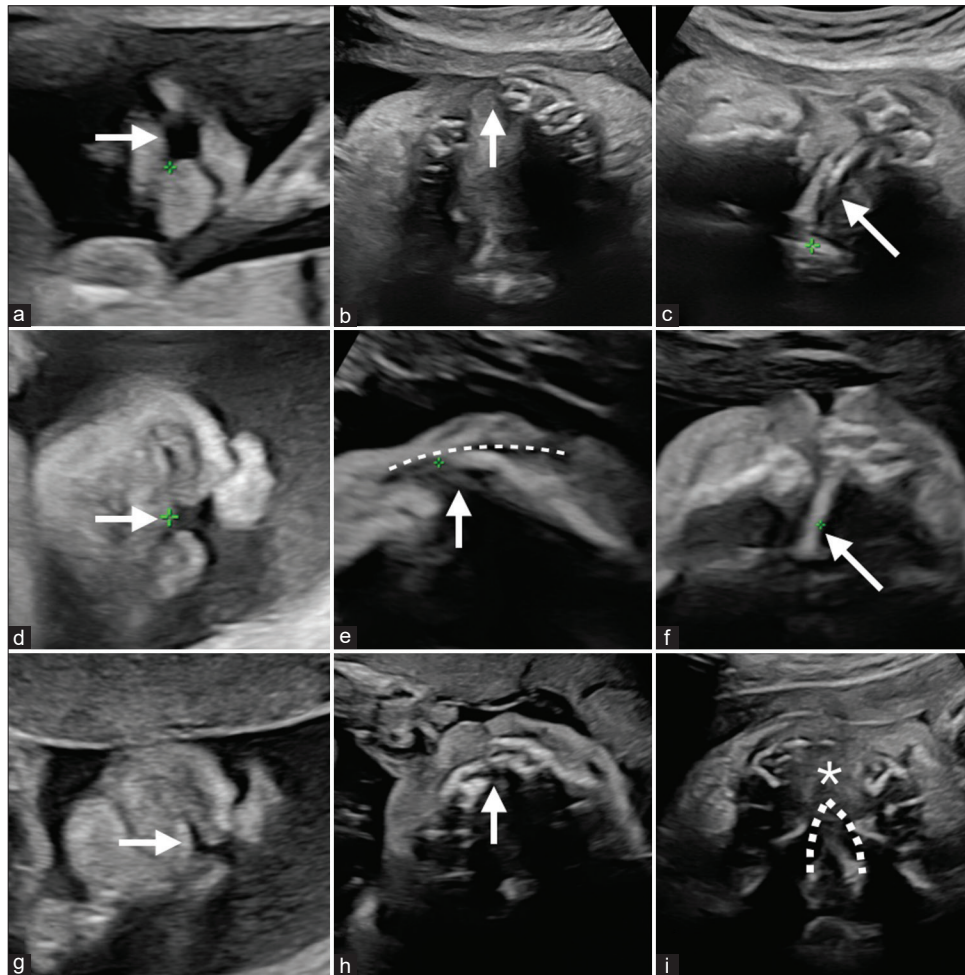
Two-dimensional ultrasound images of the lip, upper alveolus, and the posterior edge of the hard palate on the axial, and oblique axial views in a fetus at 31 weeks of gestation with complete type 3 (a-c); in a fetus at 27 weeks with incomplete type 3 (d-f); and in a fetus at 31 weeks with combined type 2 + 4 (g-i). There are certain similarities in the cleft lip (respectively for a, d, and g, arrow). However, the defect of the alveolus appears wider in complete type 3 (b). The intact nostril floor (e, dashed line) can be observed on the oblique axial view in incomplete type 3. The vomer bone deviation could be observed for incomplete and complete type 3 (c and f, arrow). In type 2 + 4, the vomer bone's visibility is limited, and the margin of the secondary palate cleft (i, dashed line) and the remaining palate (i, asterisk) can be ascertained
